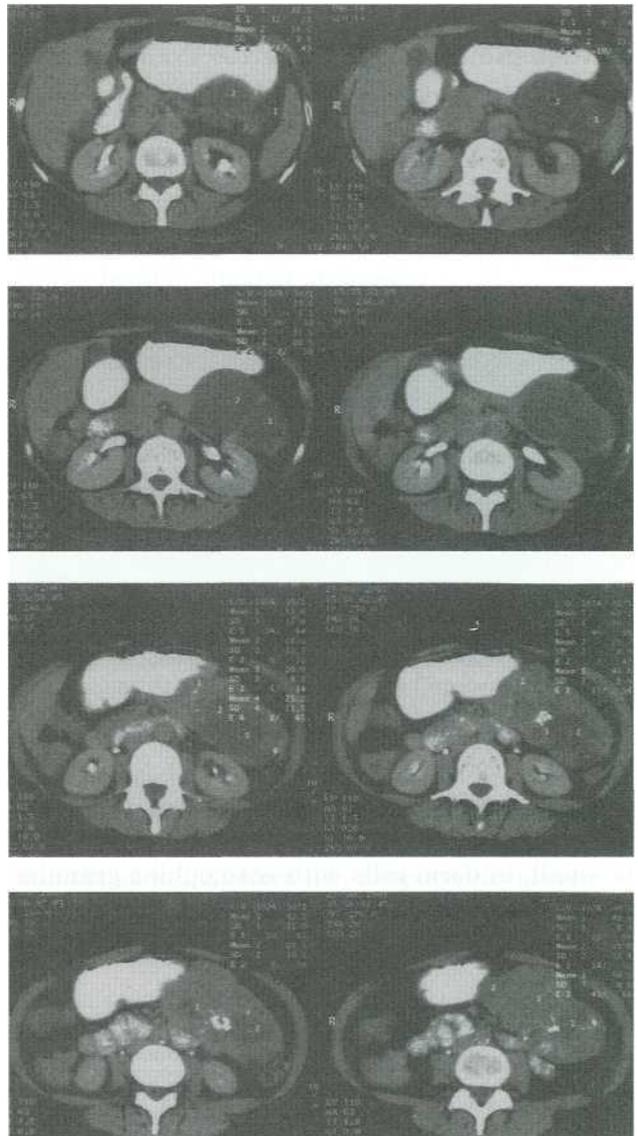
CT scan showing the SCPN of case 1 on the tail of the pancreas
